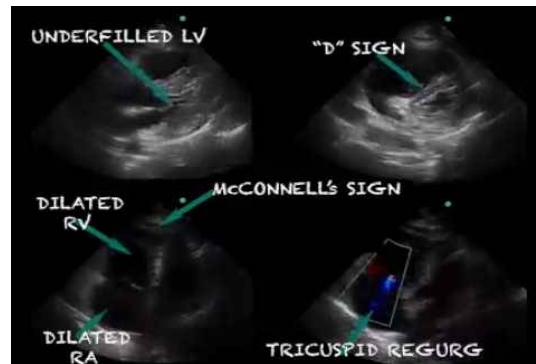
Echocardiography in Pulmonary Embolism patient
